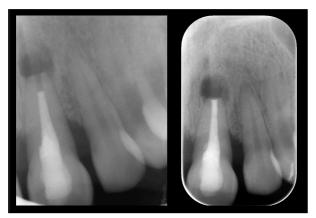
Radiograph of root-end resection and preparation
